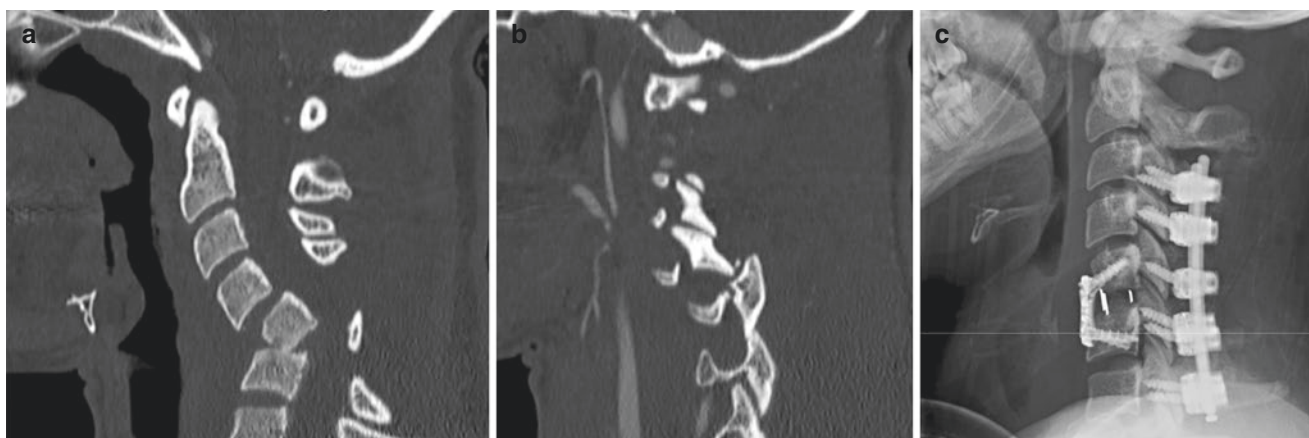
(a, b) Preoperative sagittal Computerized Tomography (CT) image of a patient with a traumatic three column cervical spine injury. (c) Post-operative lateral cervical spine X-ray. The patient underwent
